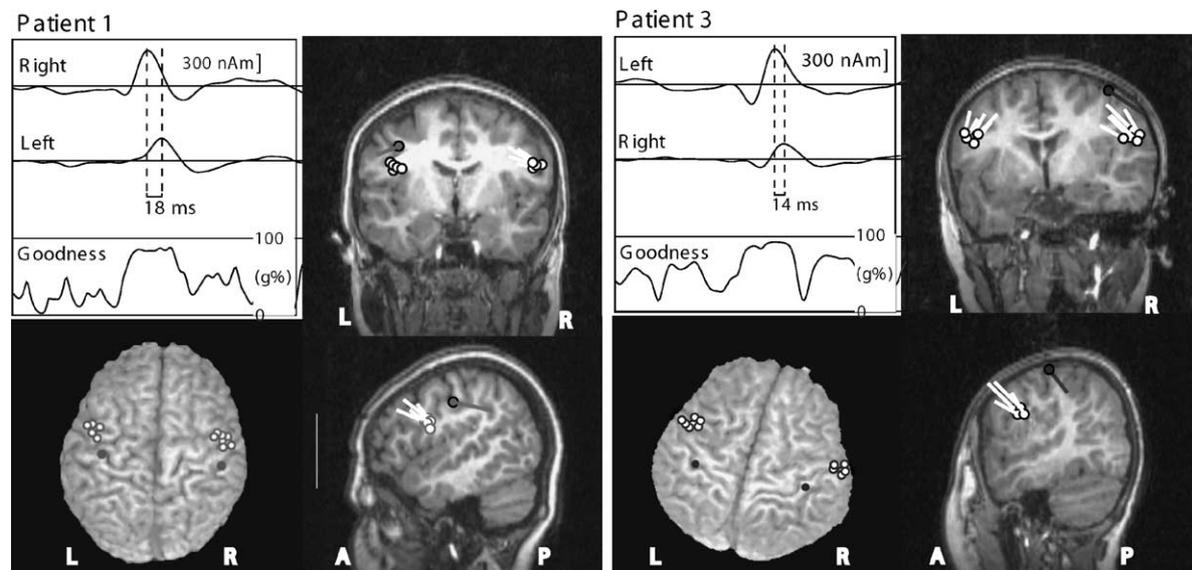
Source waveforms (left upper part in each patient's panel) of the bilaterally synchronous discharges (BSDs) as a function of time displayed in Fig. 3 from Patients 1 and 3. The interval between dashed lines indicates the peak time difference between bilateral sources. Source locations of 5–7 BSDs (white dots) are superimposed on patient's own MRI slices (right part in each patient's panel) and 3-D rendering of the brain (left lower part in each patient's panel). Sources of somatosensory cortical responses (P35m, black dots) to median nerve stimulation are also indicated for anatomical landmarks.
